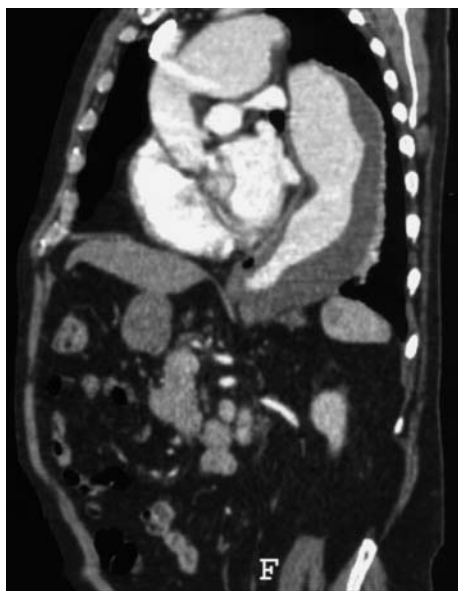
Two-dimensional reconstruction of computed tomography of the chest of a 74-year-old patient with a true distal aortic aneurysm beginning in the arch and extending into the distal thoracic aorta. A one-stage operation could be performed through the left chest. Because of the risk of embolism and the presence of chronic obstructive lung disease a two-stage approach with total arch replacement followed by distal repair seems advisable
